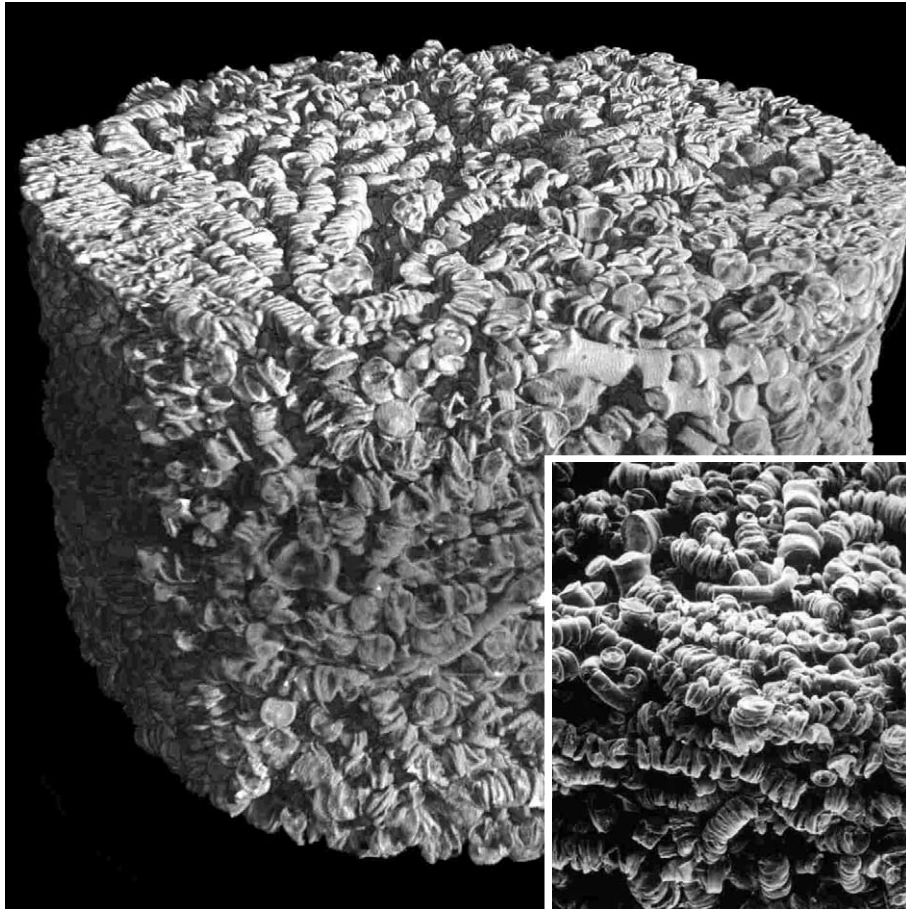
μ CT and SEM images (inset) of the outer shape of a PLGA on almost identical scale. The scaffold has a diameter of 5.0 mm and a height of 3.6 mm. The images demonstrate the complex structure of the porous sample.
